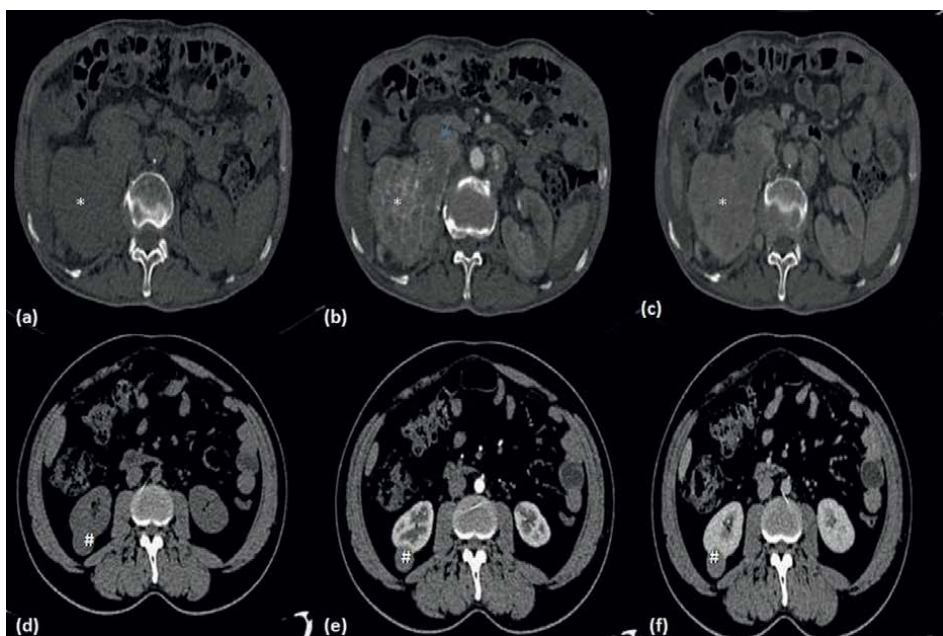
(a-c) Axial CT imaging of right renal mass- clear cell carcinoma, showing enhancement pattern on various phases. (a) Non enhanced phase shows hypodense lesion in right kidney(*) (b) similar lesion enhances heterogeneously on arterial phase(*). Thrombus within renal vein and IVC is also noted (arrow). (c) Similar lesion shows contrast wash out on venous phase(*). (d-f) Axial CT imaging of right renal mass- papillary cell carcinoma, showing enhancement pattern on various phases. (d) Non enhanced phase shows hypodense lesion in right kidney(#). (e) Arterial phase shows minimal enhancement of the lesion(#). (f) Similar lesion shows increased enhancement on venous phase(#).
